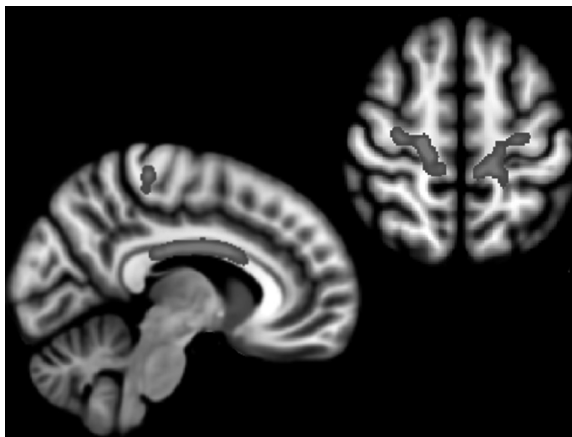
The core MRI white matter signature of MND. Areas of increased radial diffusivity in MND patients compared to healthy controls, superimposed on generic MRI images (sagittal and transverse). The core signature involves the white matter in the region of the primary motor cortices and interhemispheric motor fibres of the body of the corpus callosum.
